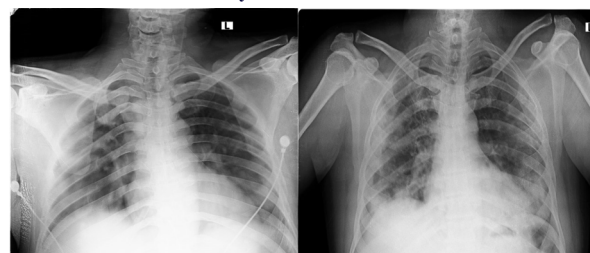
Chest x-ray findings in COVID-19: Ill-defined patchy
